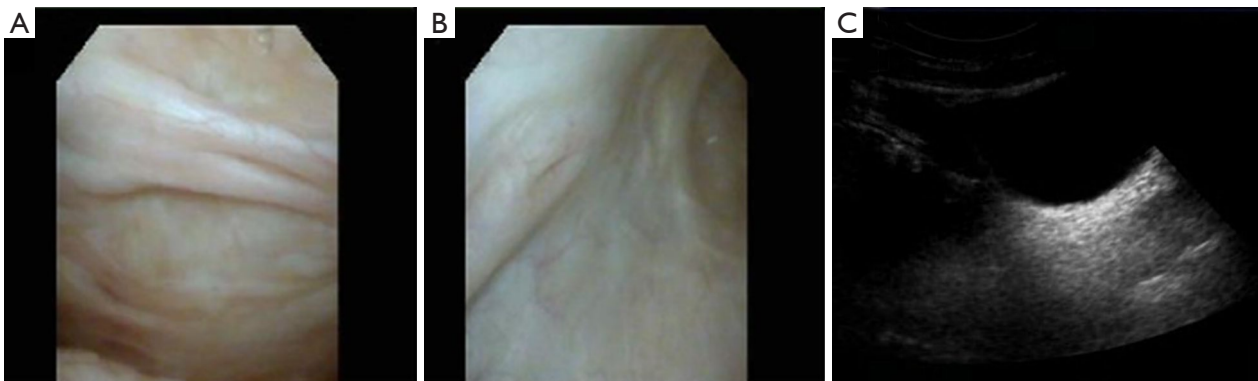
Postoperative reexamination. (A,B) Cystoscope showed postoperative scar (C) Urinary color ultrasound was normal.
